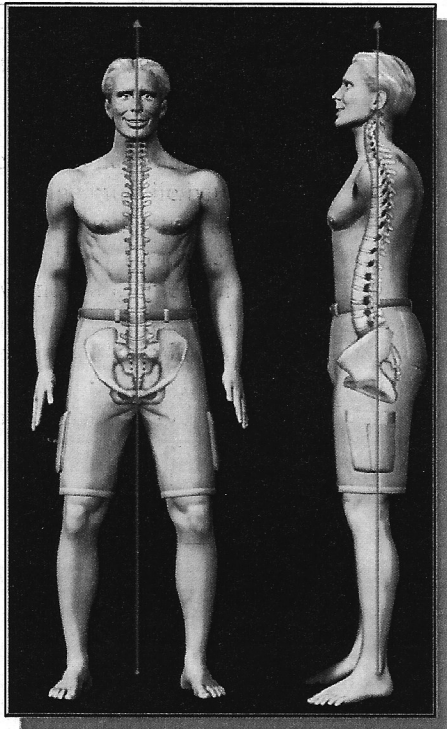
Optimal Human Posture and Spinal Alignment. From the front view, optimum position for the spine is vertical alignment or straight up and down. Optimal posture is vertical alignment of the center of the head, ribcage, and pelvis and the gravity line must lie between mid-stance. The reader should notice that the spine is a straight line from the front. From the side view, optimal posture is vertical alignment of the three postural components (head, thorax, and pelvis) and these must line up with the mid ankle. The reader should notice that the spine has three curves from the side: a cervical lordosis, a thoracic kyphosis, and a lumbar lordosis. Only an X-ray can show the curvature of the spine from the side; but posture gives us clues.
